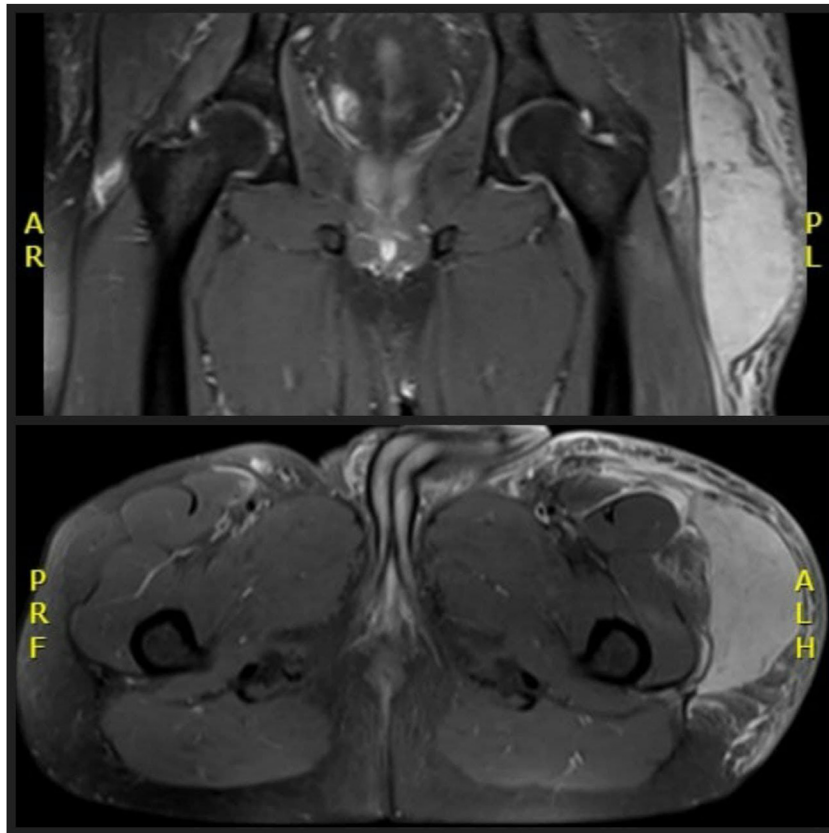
MRI pelvis + thigh.
